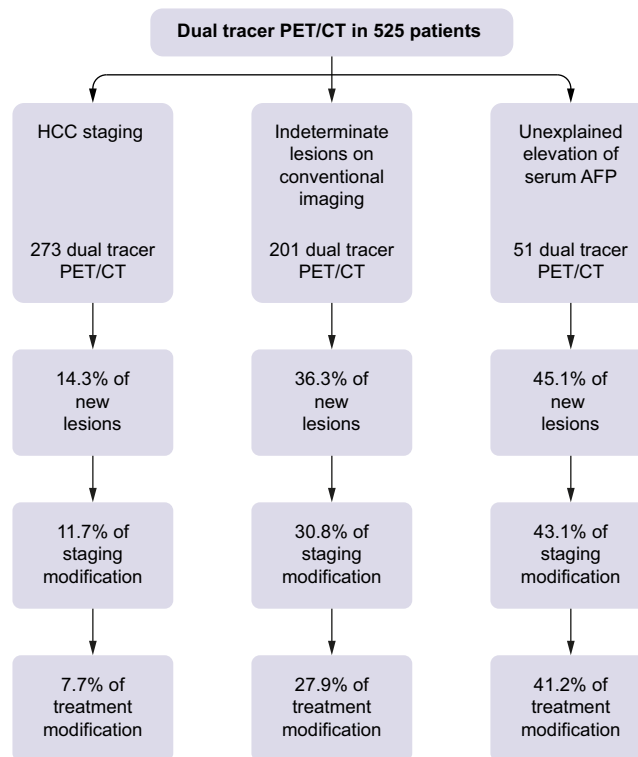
Impact of dual-tracer PET/CT on identification of new lesions and modification of staging and treatment allocation (N = 559 scans in 524 patients).
